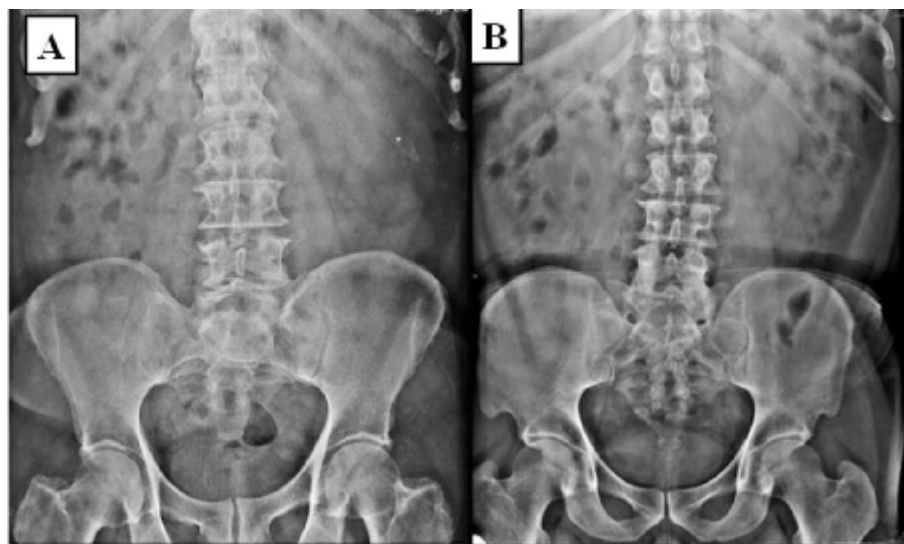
Lumbosacral AP Radiographs (A and B): showing normal transverse processes of L5 vertebra and normal S1 vertebra.
